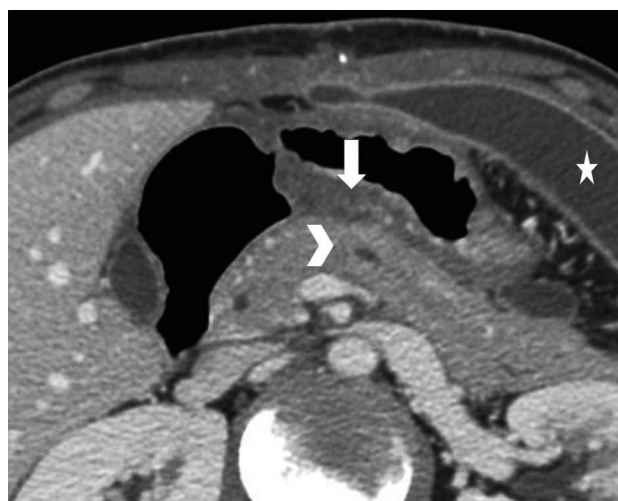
Axial CT image in 19-year-old man shows linear low density of pancreatic fracture through both surfaces of pancreatic body (*arrowhead*). The peripancreatic fat is misty (*arrow*), with evidence of intra-abdominal collection (*star*)
